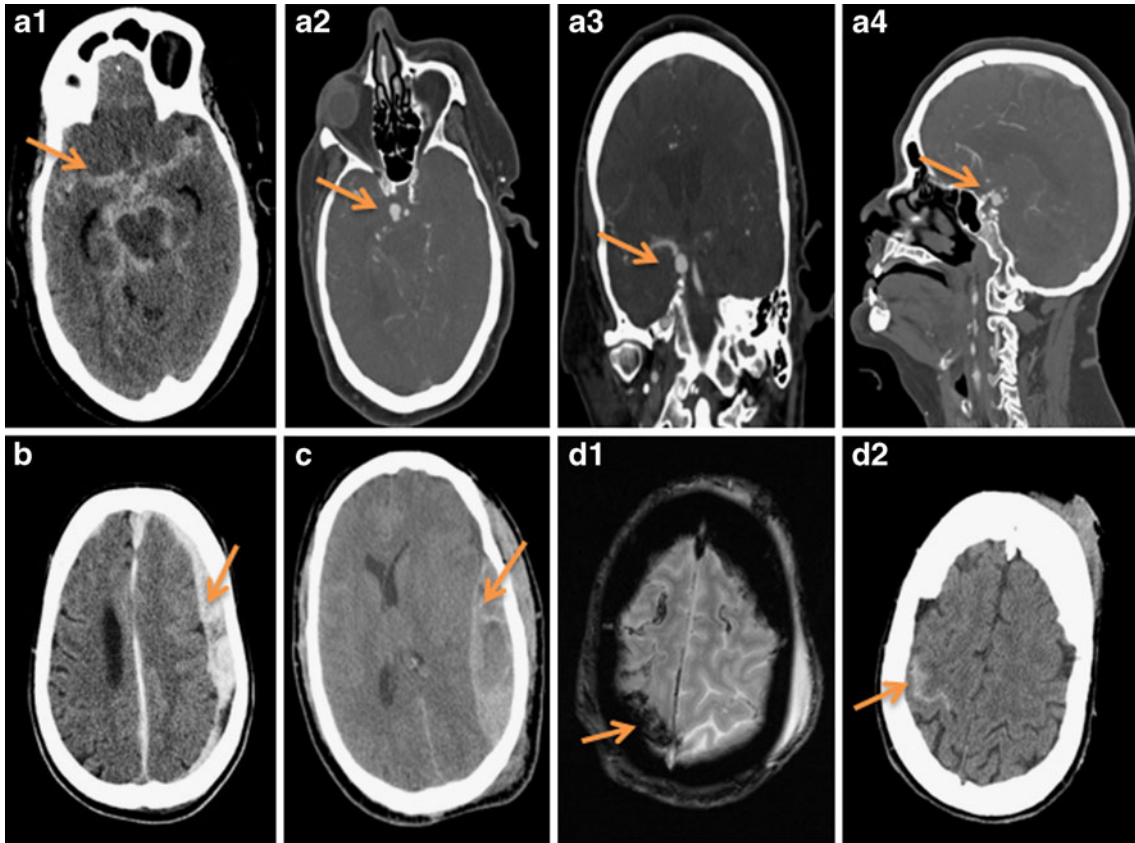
Examples of subarachnoid, subdural, and epidural hematoma (arrows). (a1) Subarachnoid hemorrhage (CT), (a2, a3, a4) axial, coronal, and sagittal views of right posterior communicating artery aneurysm (CT angiography), respectively, (b) left subdural hemorrhage (CT), (c) left epidural hematoma (CT), (d1, d2) traumatic subarachnoid hemorrhage (CT and GRE). (High resolution version of this image is available in the [electronic supplementary material](#).)
